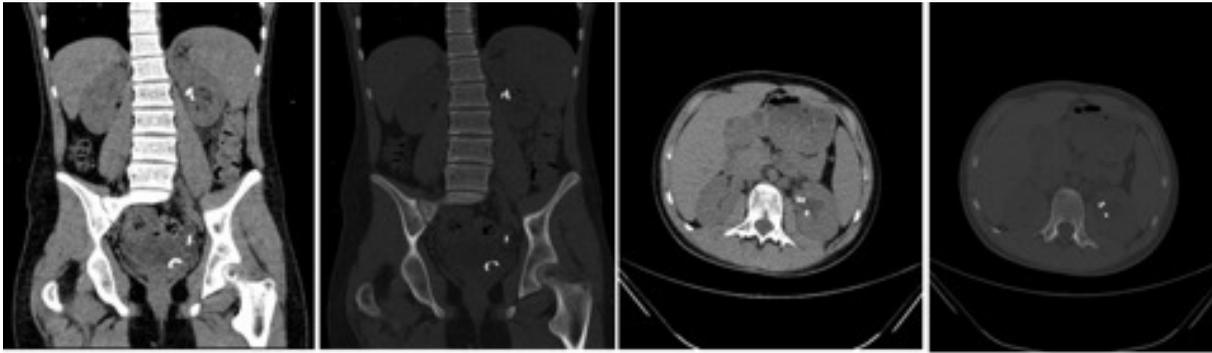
Post-operative control CT images
